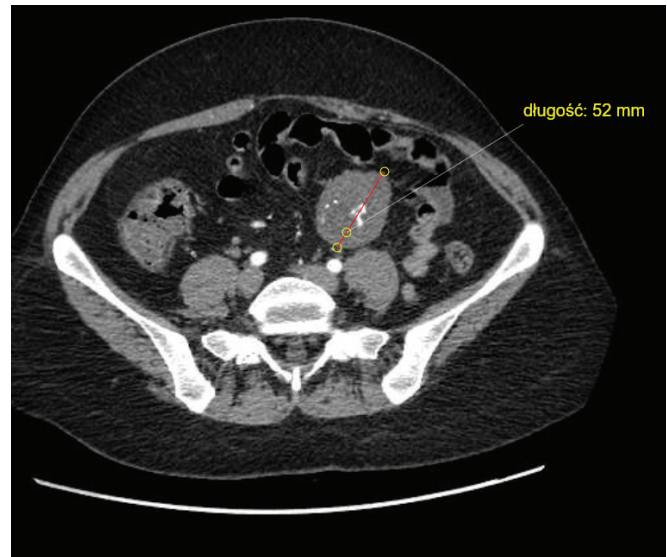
Tumour appearance on abdominal computed tomography
